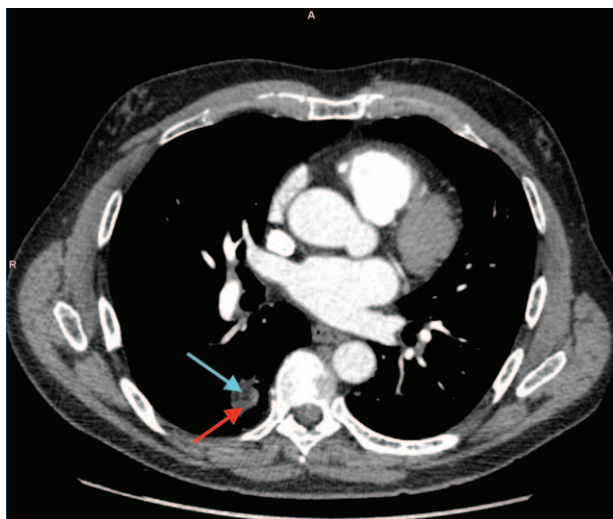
Chest HRCT revealing the pulmonary nodule had heterogeneous densities with mostly fat densities (–30 Hounsfield units on blue arrow; 40 Hounsfield units on red arrow). HRCT = high-resolution computed tomography.
